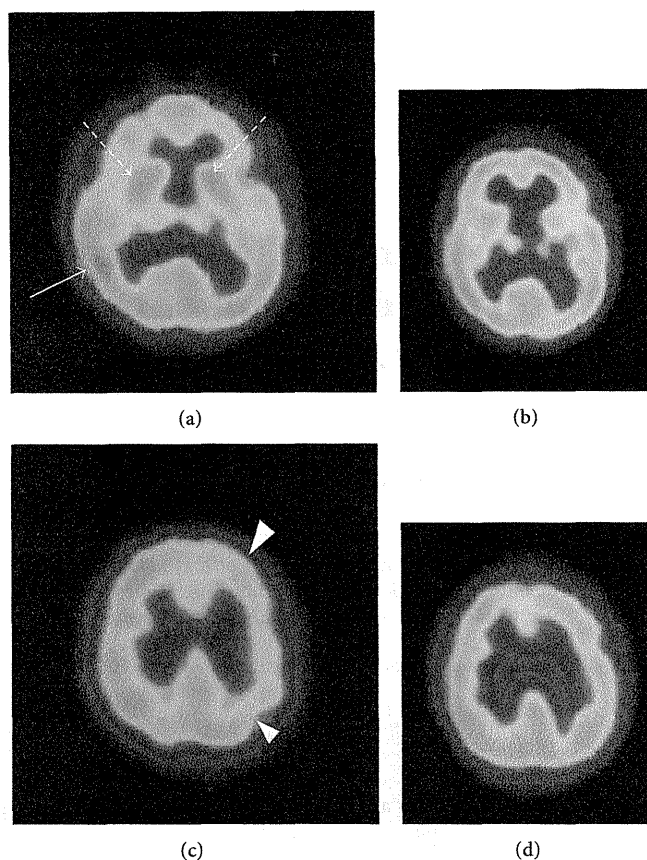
$^{99m}\text{Tc}$ -HMPAO-SPECT images acquired during a seizure and 10 days later. (a) and (c) show relative hyperperfusion in the right parietal lobe (arrow) and both thalami (dotted arrows) and relative hypoperfusion in the left prefrontal and parietal lobes (arrow heads) during a seizure. (b) and (d) are the same axial slices as (a) and (c), respectively, obtained 10 days after the final seizure. In (b) and (d), relative hyperperfusion and hypoperfusion are not noted, as bilateral symmetrical cerebral perfusion has been normalized.
